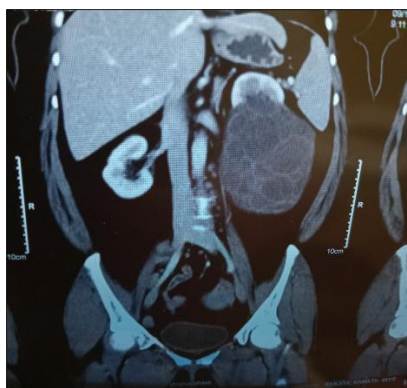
CT Abdomen & Pelvis: Large hypodense multilocular cystic lesion arising from the left kidney.
